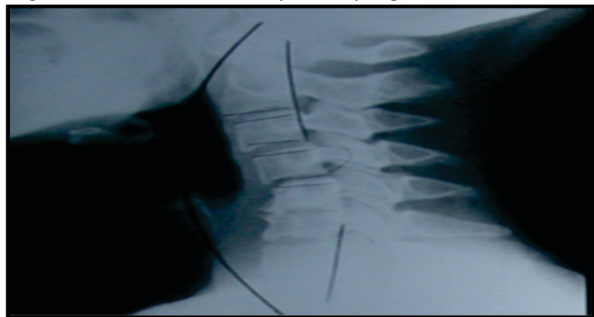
Simple radiograph demonstrating C4-C5 subluxation as well as C5-C6 degenerative spondylosis in a patient with symptoms of CSM.
